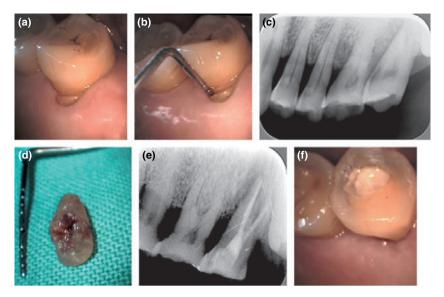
(a) Swelling over the palatal side of tooth 27 and concomitant root fracture. (b) Periodontal probing revealed the presence of a deep pocket. (c) Radiographic examination showed a diffuse radiolucent lesion around the tooth. (d) Extracted palatal root showing oblique fracture. (e) Radiographic evaluation of root canal treatment. (f) Clinical picture of the tooth, 2 months after initial treatment showed adequate short-term healing.
